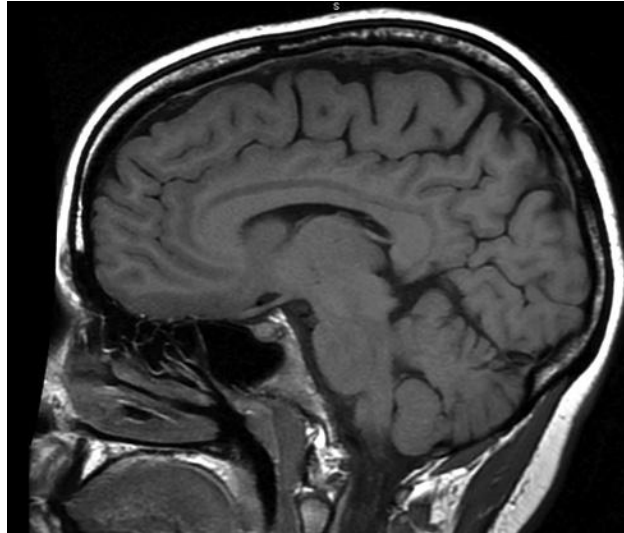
MRI normal brain in sagittal view. The nose is on the left. Notice how clearly the fissures and folds over the surface of the brain can be seen, as well as the distinction between the different neural elements of which the brain is composed.
